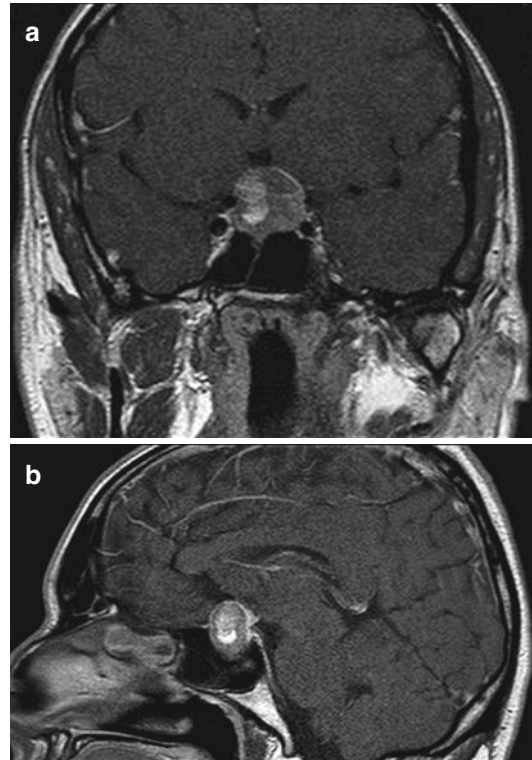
A 39-year-old healthy male with a typical presentation of pituitary apoplexy. On admission he had headaches and bitemporal upper quadrantanopsia (left>right). MRI depicted a large pituitary adenoma with suprasellar extension and chiasmal compression. Pituitary haemorrhage is seen on coronal (a) and sagittal (b) T1-weighted images in the right side of the adenoma. Hormonal evaluation before operation revealed low cortisol and low testosterone levels that returned to normal after pituitary decompression. Pathology report was compatible with apoplexy of a nonfunctioning pituitary adenoma
